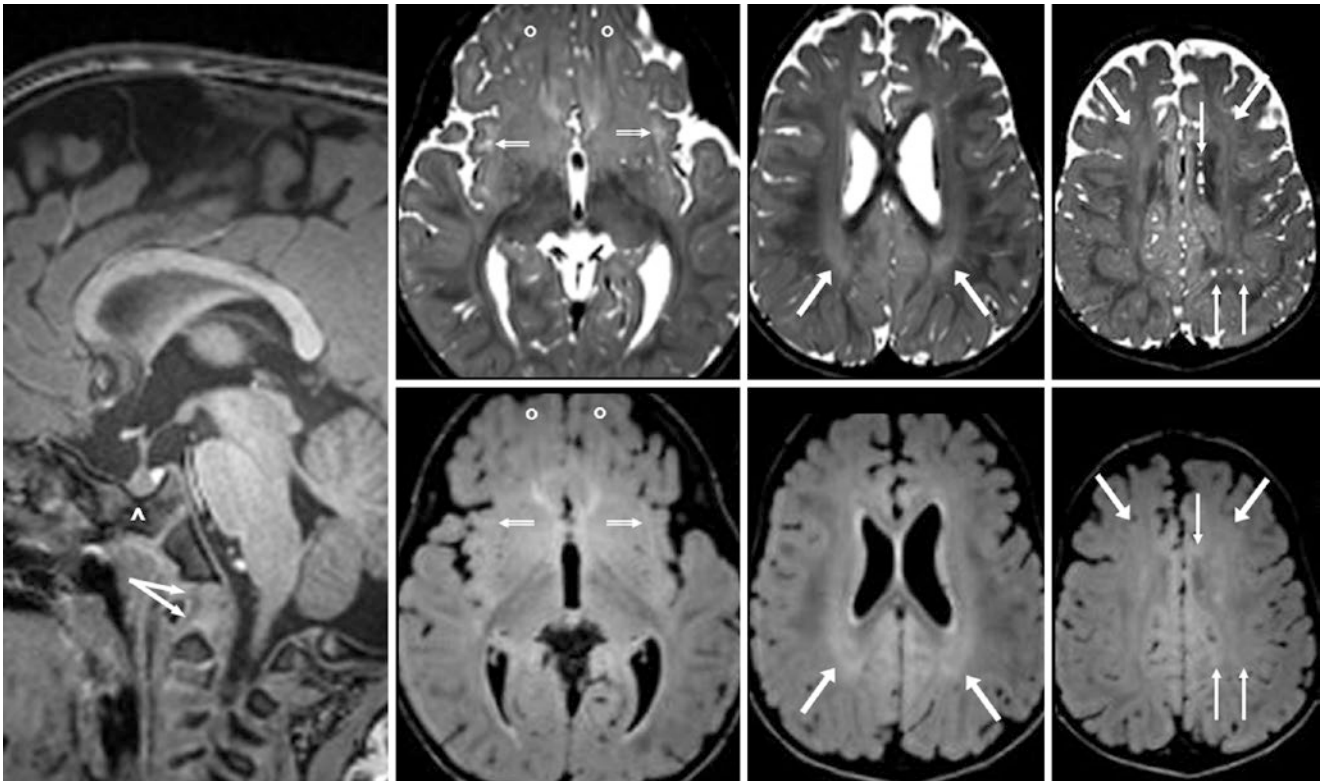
Comparison case of Hurler's mucopolysaccharidosis. A 17-month-old had a 3T MRI that showed a "J-shaped" bony sella (^) with odontoid capping (*split arrows*) on a sagittal GE T1WI (*left*). On axial 3D SE T2WIs (*top row*) and 3D FLAIR (*bottom row*), the OFWM
